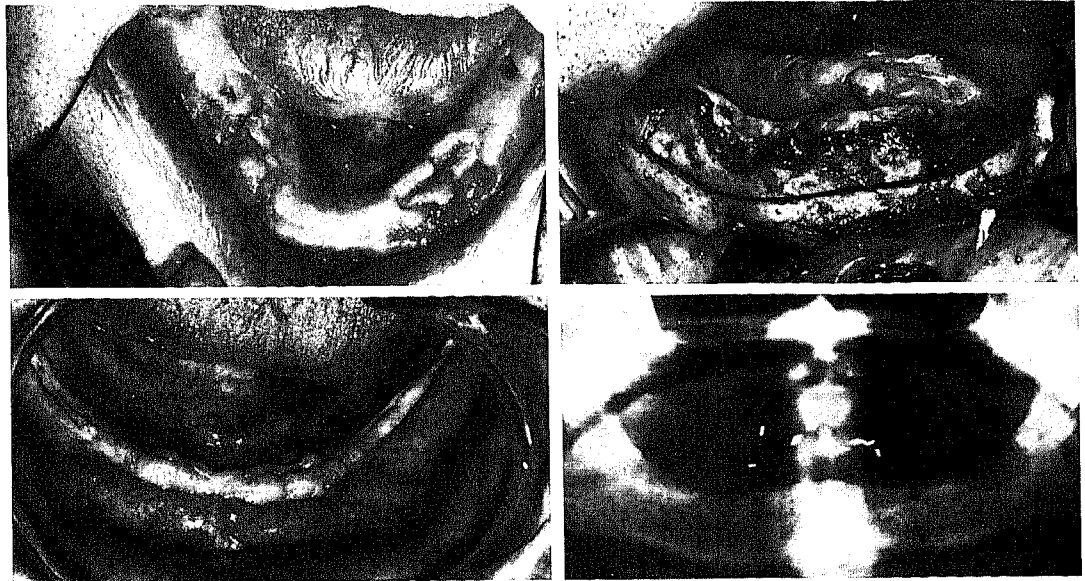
Above, left*, osteoradionecrosis that did not respond to Stage I therapy. *Above, right*, transoral alveolar resection as part of Stage II therapy. *Below, left*, healed mucosa after Stage II therapy. *Below, right*, radiograph of mandible after Stage II therapy, showing structural integrity and quantity of remaining bone.
